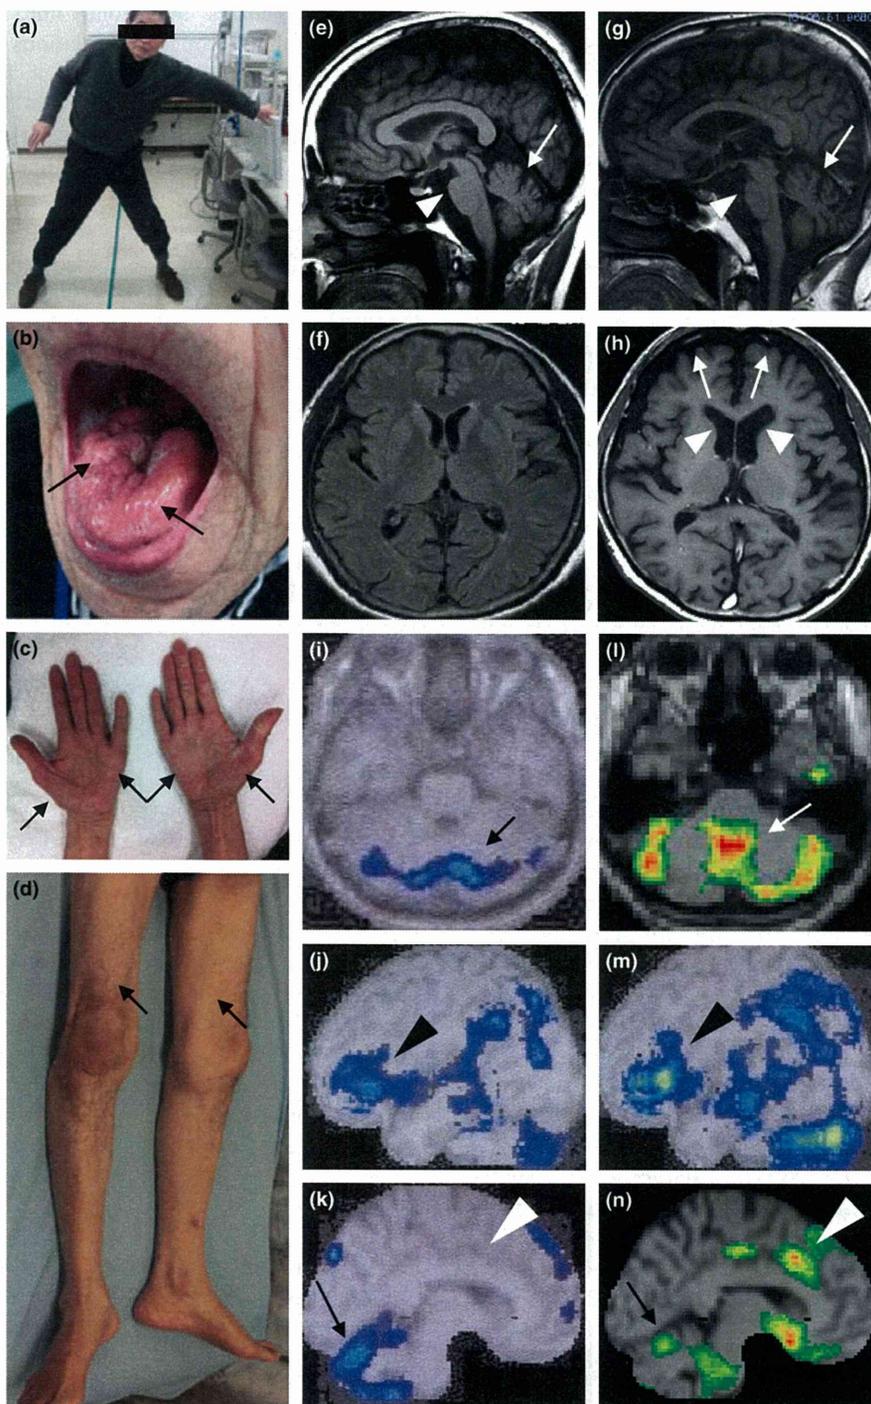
(a–d) Typical physical pictures of Asidan patients with a strong standing/walking disability (a), tongue atrophy with fasciculation (b, arrows), thenar and hypothenar atrophies (c, arrows), and leg atrophy with fasciculation (arrows). Magnetic resonance imaging MRI images with an early stage patient (e, f) and an advanced stage patient (g, h). Note cerebellar atrophies (e and g, arrows) without brain stem atrophy (e and g, arrowheads), and frontal lobe atrophy in the advanced stage (h, arrows) with corresponding anterior horn dilatation (h, arrowheads). Examples of eZIS analysis with ^{99m}Tc -ECD-SPECT in an early stage patient (i–k) and an advanced stage patient (l–m) show rCBF reduction in cerebellar vermis and hemisphere from the early (i and k, arrows) to advanced stage (l and n, arrows) and also show the progressive rCBF decline in Brodmann areas 44–46 (j and m, arrowheads) with decline in Brodmann area 24 only at the advanced stage (k and n, arrowheads).
